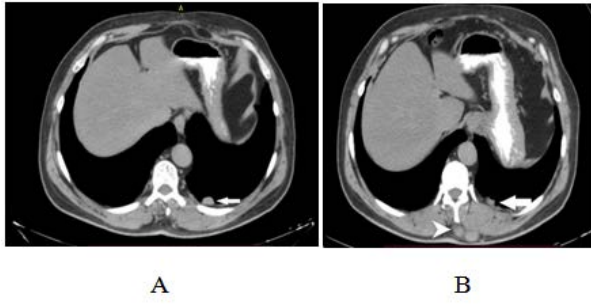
Non-enhanced abdominal CT Axial images showing a rounded pleural-based soft tissue nodule (A, B. white arrows) and multiple solid nodular subcutaneous lesions at the left upper abdominal wall (B. white arrowhead)
